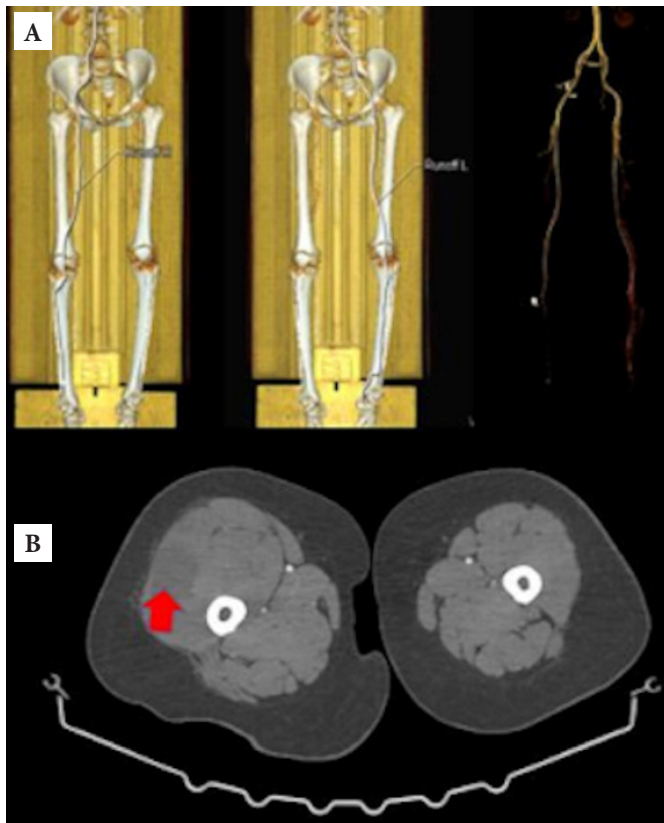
a: Computed tomography angiogram scan views. b: Computed tomography view showing a large hematoma in the right thigh (red arrow).
